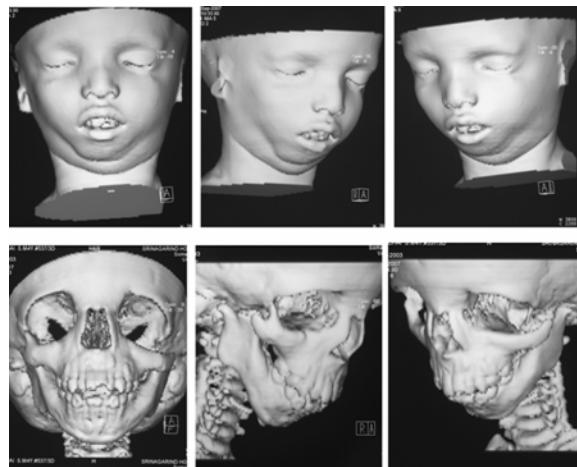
Three-dimensional CT (3-D CT) reconstruction (lower row) with Shaded Surface Display (SSD) (upper row) of patient No. 3 showing bilateral hypoplasia of the zygomatic bones and mandible, and downward slanting of the lateral orbital wall
